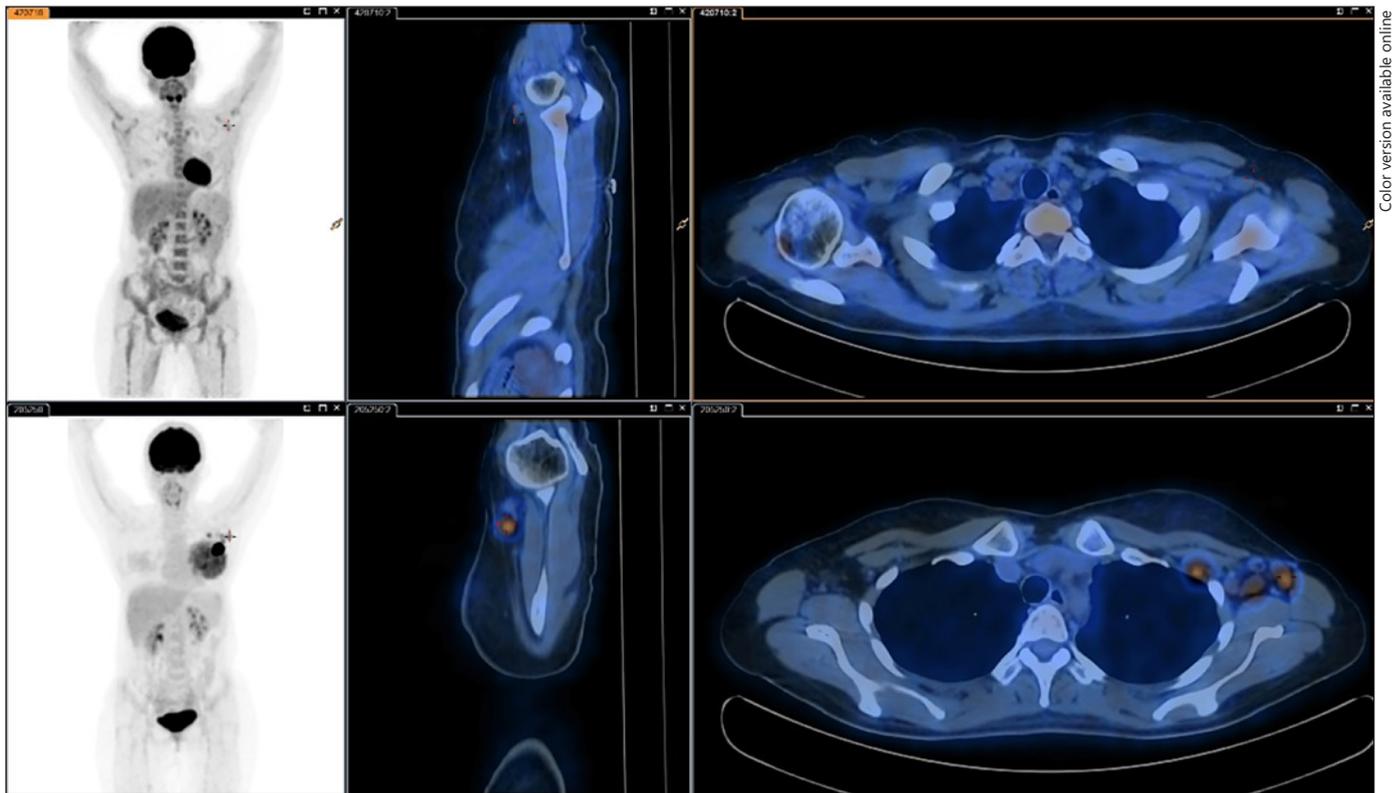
18F-FDG PET/CT images of a 38-year-old woman with locally advanced HER2-positive and ER-positive breast cancer. Before NAC (lower image), the images show the FDG uptake in both breast and axillary tissue. After the patient received chemotherapy with a dual-blockage regimen (upper image), the images show metabolic and anatomical regression by which after-surgery pCR was obtained.
